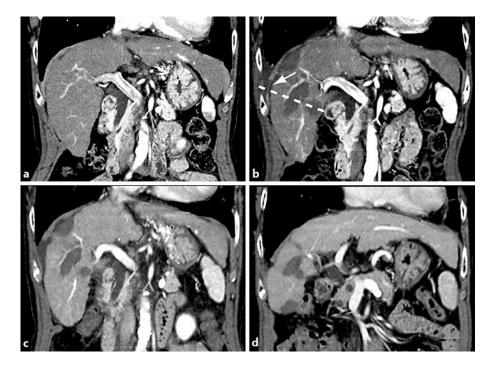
Findings on coronal CT. Preablation (a) and postablation (b) images of RFA performed 33 months before the onset of diaphragmatic hernia. The dotted line indicates the estimated needle track for RFA. Diaphragmatic thinning along the needle track is shown (arrow). c Diaphragmatic perforation is depicted 24 months before the onset of diaphragmatic hernia. d Both the progression of the liver atrophy and diaphragmatic perforation are demonstrated 4 months before admission.
